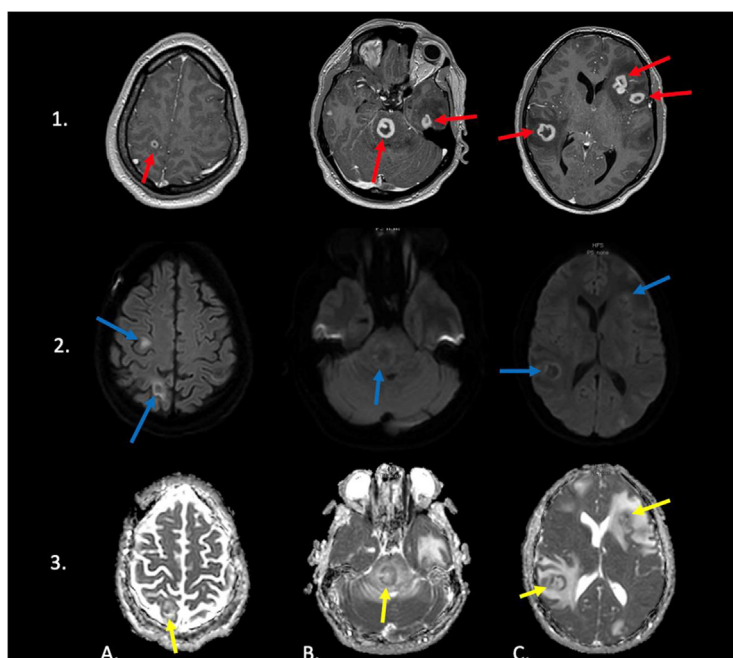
Up to 37% of PCNS-PTLD lesions demonstrate restricted diffusion within the solid components of the lesion [1]. Figure 11 shows axial sections of an IV contrast enhanced brain MRI. Row 1 shows axial sections of a T1 weighted post-gadolinium sequence, with enhancing lesions (red arrows). Row 2 shows axial sections of a DWI b1000 image, with high signal corresponding to some of the solid, enhancing components of the lesions shown in column 1 (blue arrows). Row 3 shows the corresponding ADC sequences, with low signal corresponding to some of the enhancing components, referring to lesions demonstrating true restricted diffusion (yellow arrows).
